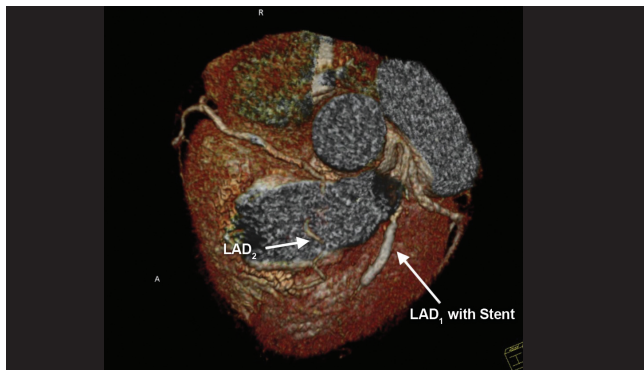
Multi-detector computed tomography coronary angiography of the dual LAD is presented herein, revealing a separate origin from the RCS of LAD₁.
